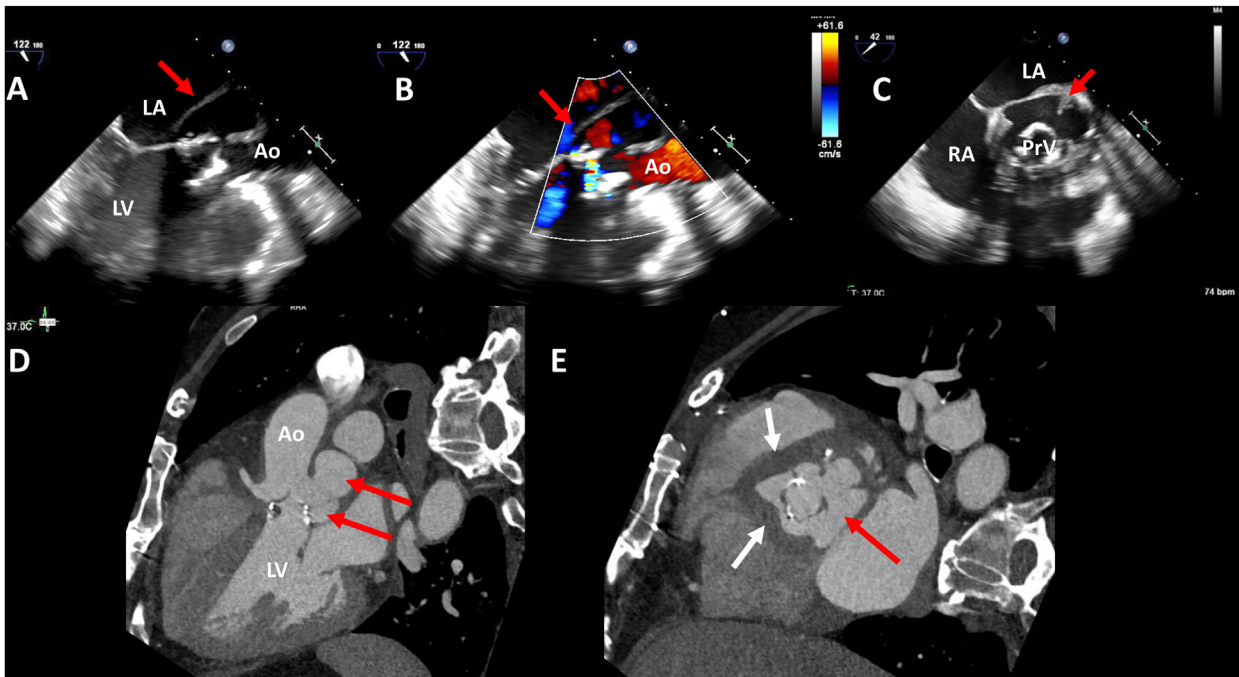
A case of a bioprosthetic aortic valve (AV) complicated by a large aortic root pseudoaneurysm imaged with TEE and computed tomographic angiography. Midesophageal long-axis views (A, B) and short-axis view (C) show a large pseudoaneurysm (arrows). The valve has evidence of calcification but no discrete vegetations. (B) Same view with color Doppler showing eccentric paravalvular regurgitation in diastole. (D) Cardiac computed tomographic angiographic sagittal view shows dehiscence below the left cusp with a large pseudoaneurysm (two red arrows). (E) Modified sagittal view shows circumferential hypodensity on the aortic root suggestive of root abscess (white arrows). There is mild thickening and calcification of the bioprosthetic AV (visualized in systole). The pseudoaneurysm is seen over the left sinus (red arrow). Ao, Aorta; LA, left atrium; LV, left ventricle; PrV, prosthetic valve; RA, right atrium.
